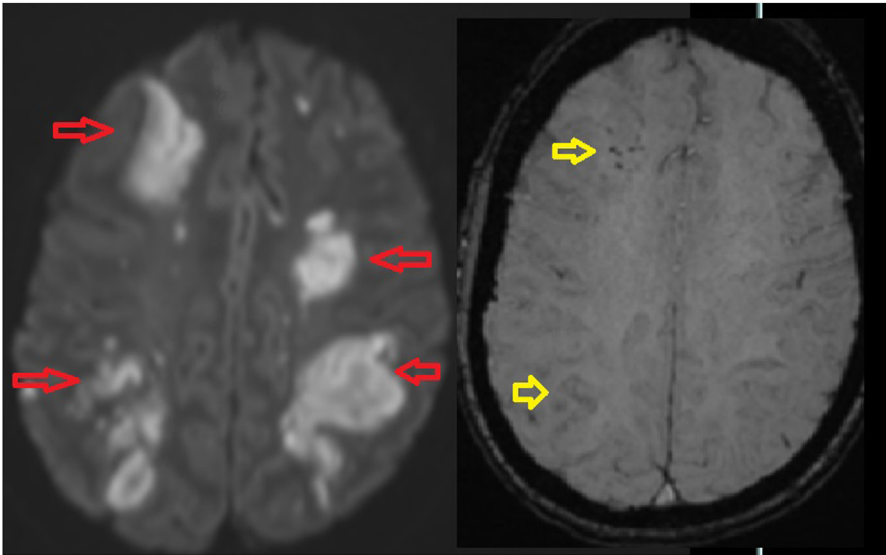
Axial diffusion-weighted (A) and susceptibility-weighted (B) MRI of the brain of a 52-year-old woman with multiple infarctions secondary to RCVS (red arrows) with petechial hemorrhagic changes (yellow arrows) on susceptibility-weighted sequence.
